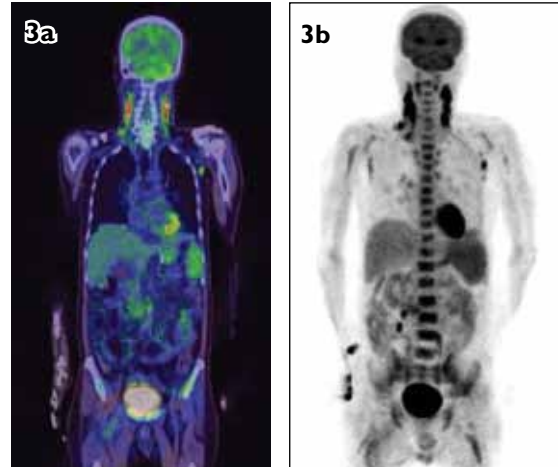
(a) PET/CT and (b) MIP images show increased FDG uptake in the cervical lymph nodes in Case 2.
